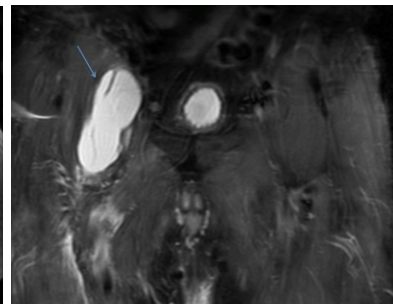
Coronal MR image depicting the enlarged IB, aiding with planning of surgical approach.
